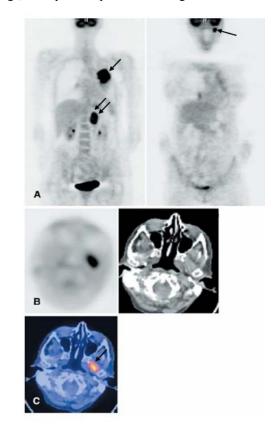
Registered and fused FDG PET and CT scans of a patient with lung cancer and an adrenal gland metastasis. (a) Coronal PET images show typically increased FDG uptake in the primary lung tumor (*single arrow in left panel*) and in the metastasis in the left adrenal gland (*double arrow in left panel*) but also in the left side of the neck (*arrow in right panel*). (b) Transaxial PET and CT images through this neck
